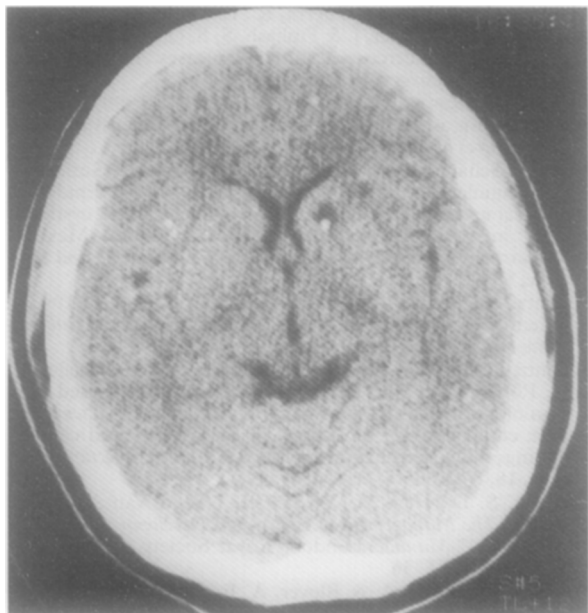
Computed tomography scan showing multiple cysticercosis cysts in the brain of a seropositive epileptic individual.
